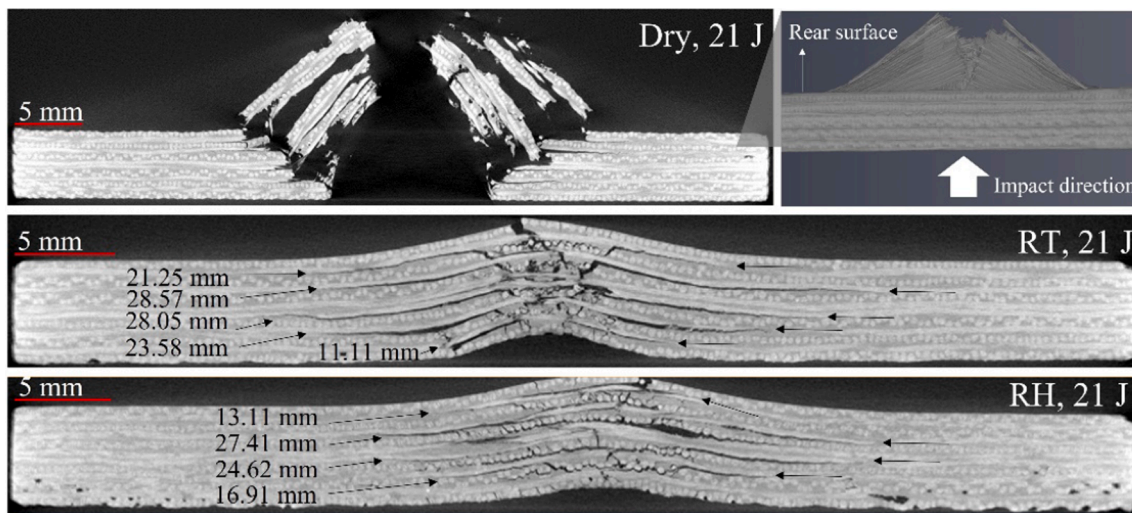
Non-destructively captured internal damage patterns, including delamination lengths based on X-CT. (For interpretation of the references to colour in this figure legend, the reader is referred to the web version of this article.)
